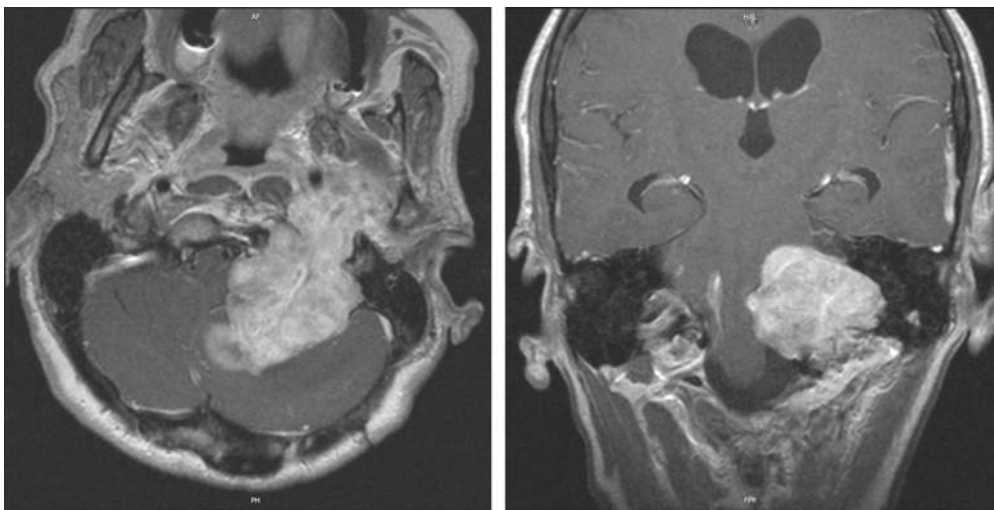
Axial (*left*) and coronal (*right*) T1-weighted Gd-enhanced MRI demonstrating a large hypoglossal neurinoma with brainstem compression. Note the extracranial extension of the tumor
